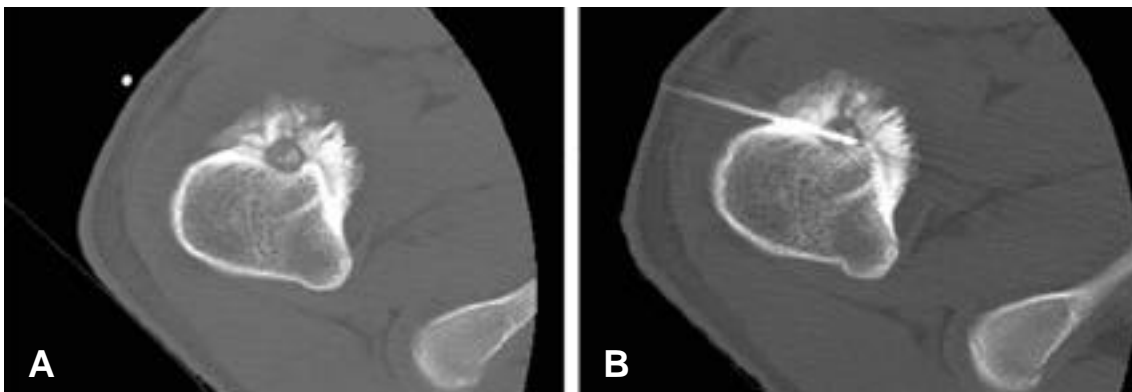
(A) CT image of the lesion in the proximal femur (B) A radio-frequency electrode inserted within the lesion
